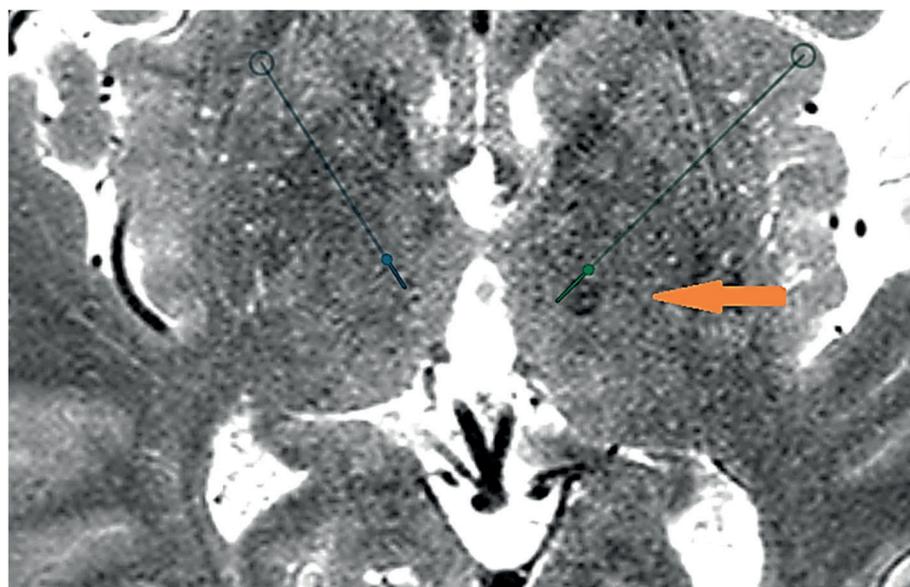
Axial MRI projection of patient H., who underwent RF thalamotomy on the right (orange arrow); calculation of coordinates of STN nuclei for subsequent implantation of electrodes for bilateral neurostimulation
